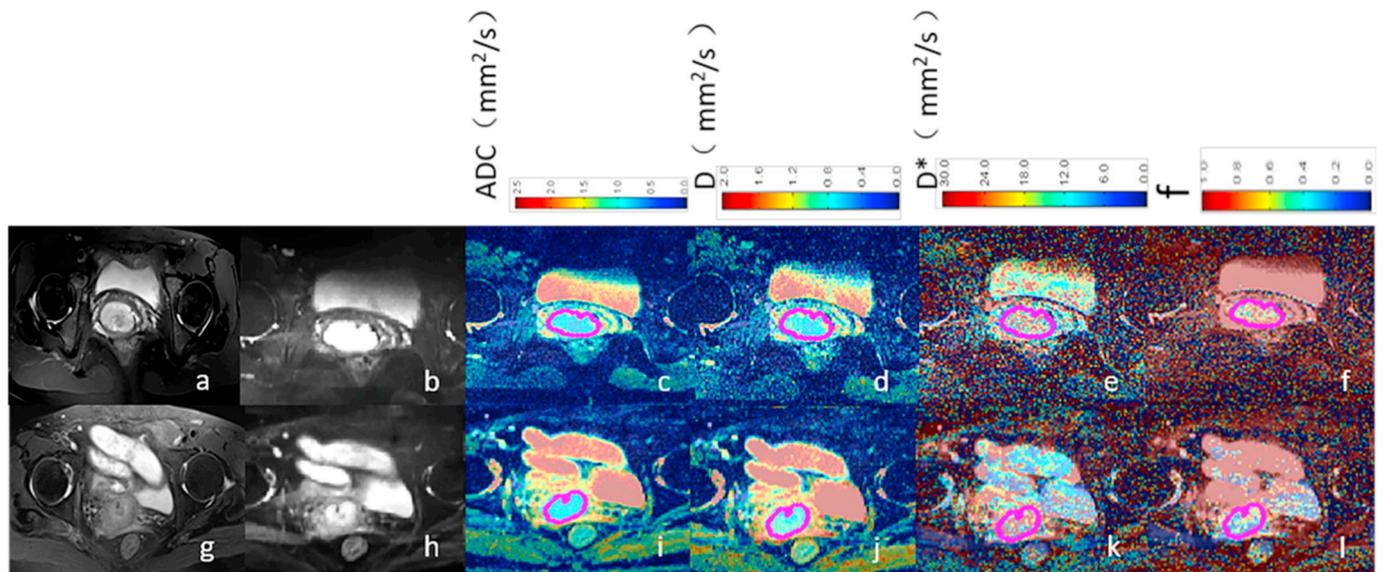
A 41 years old patient with cervical squamous cell carcinoma, clinical stage I_B (a–f). Another 61 years old patient with cervical squamous cell carcinoma, clinical stage II_B (g–l). (a) Axial FS hyperintense T2-weighted image, (b, h) Axial DW images. (c, i) Axial ADC maps. (d, j) Axial D map. (e, k) D* map. (f, l) f map values. (g) Axial FS hypointense T2-weighted image. Values obtained for clinical stage I_B and clinical stage II_B cervical cancer were as follows: ADC: $1.10 \times 10^{-3} \text{ mm}^2/\text{s}$ and $0.88 \times 10^{-3} \text{ mm}^2/\text{s}$; D: $1.00 \times 10^{-3} \text{ mm}^2/\text{s}$ and $0.85 \times 10^{-3} \text{ mm}^2/\text{s}$; D*: $21.02 \times 10^{-3} \text{ mm}^2/\text{s}$ and $31.63 \times 10^{-3} \text{ mm}^2/\text{s}$; and f: 0.17 and 0.11, respectively.
